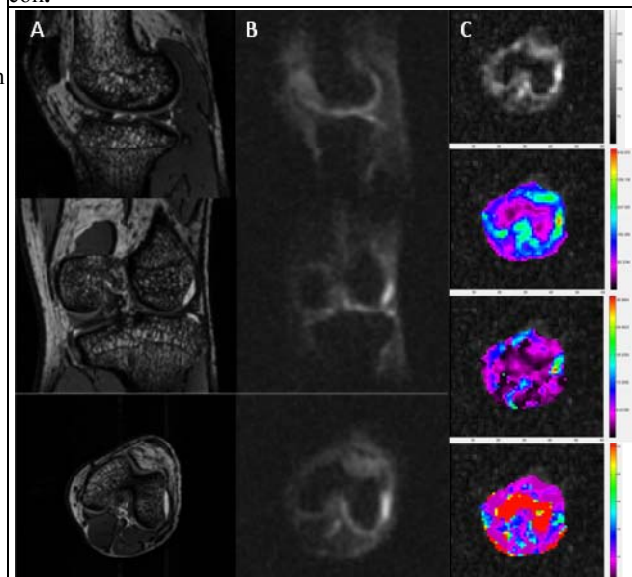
In-vivo proton and sodium MR imaging of normal human knee. A, Proton DESS MR image; sagittal, coronal, and axial view. B, Corresponding sodium MR images. C, T2 map in axial view - sodium density (first two rows), intra-cellular sodium and extra-cellular sodium T2 from top to bottom.
